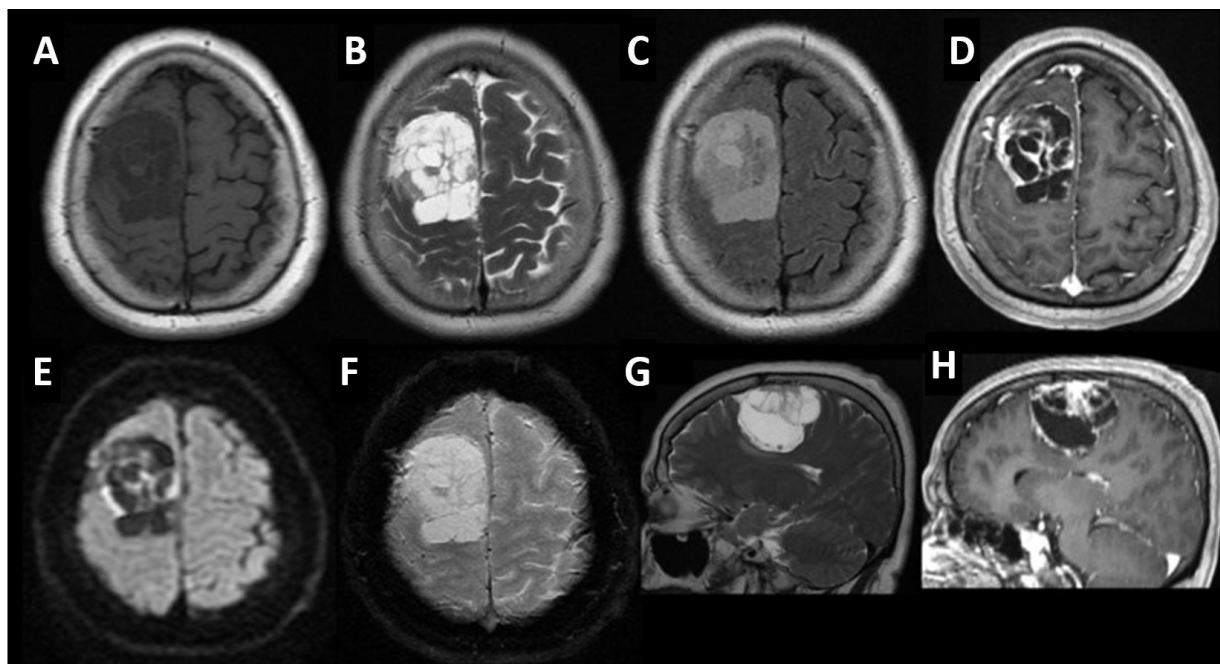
MRI identifying the extra-axial broad-based lesion hypointense on T1 (A), hyperintense -due to the extensive cystic component with multiple septa- on axial T2 (B) and sagittal T2 (G), hyperintense on FLAIR (C), with notorious enhancement of the septa and the central solid portion on contrast-enhanced axial (D) and sagittal (H) T1 sequence. Diffusion-weighted imaging shows peripheral areas of restriction (E), without hemorrhagic residues or calcific deposits on SWI (F).
